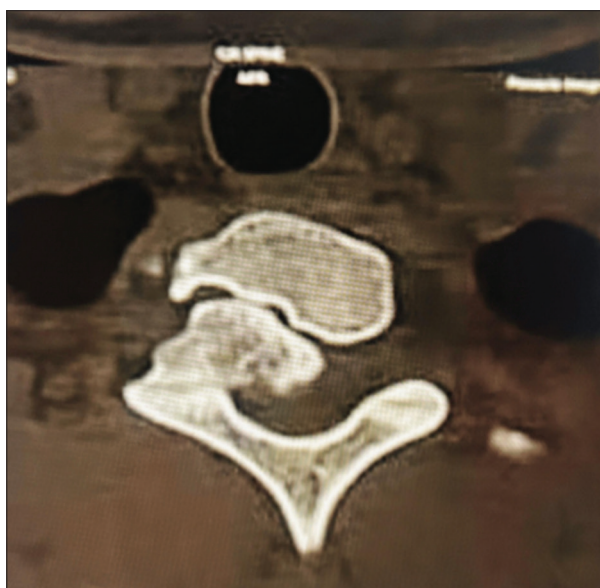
An axial computed tomography image shows a pedunculated osseous lesion arising from the right pedicle/ of T2 that is continuous with the medullary cavity, consistent with an osteochondroma. The lesion is extending into the central canal, causing severe central canal stenosis, spinal cord impingement, and right neural foramina narrowing
